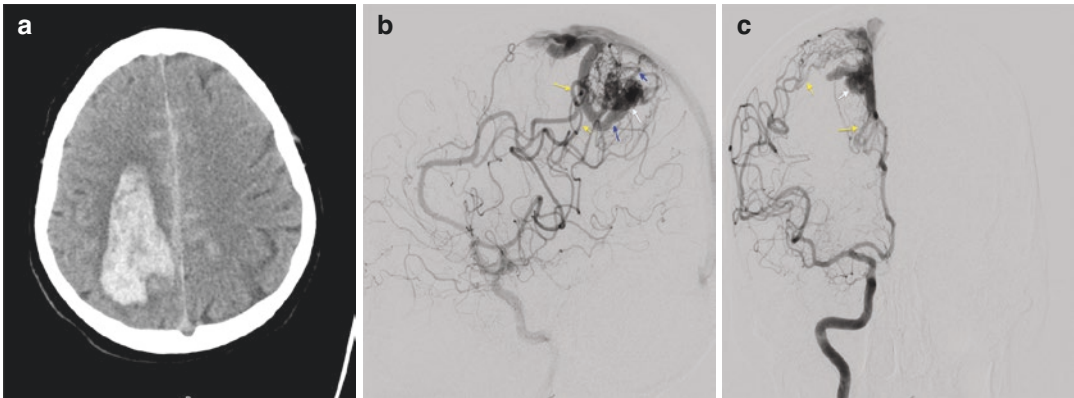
(a) CT scan showing and AVM presenting with intraparenchymal hemorrhage and subarachnoid hemorrhage. (b, c) Conventional DSA demonstrating the AVM
